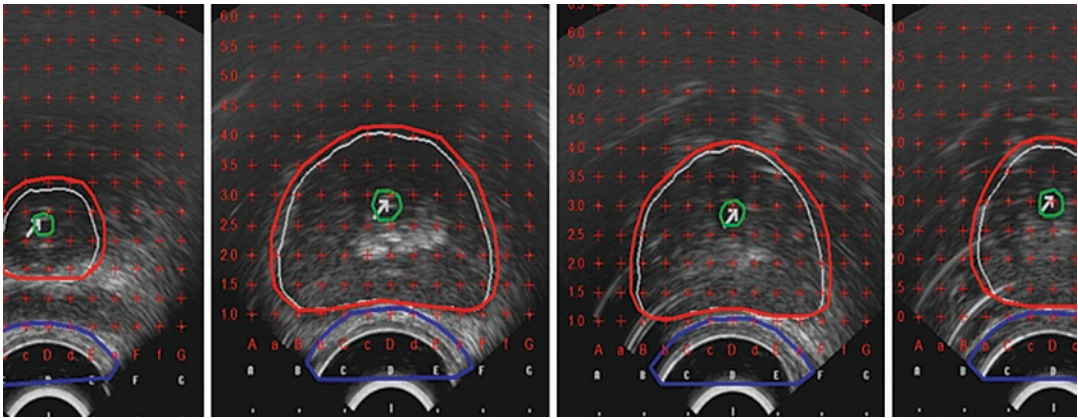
Intra-operative transrectal ultrasound guided volume study from base to the apex of prostate
